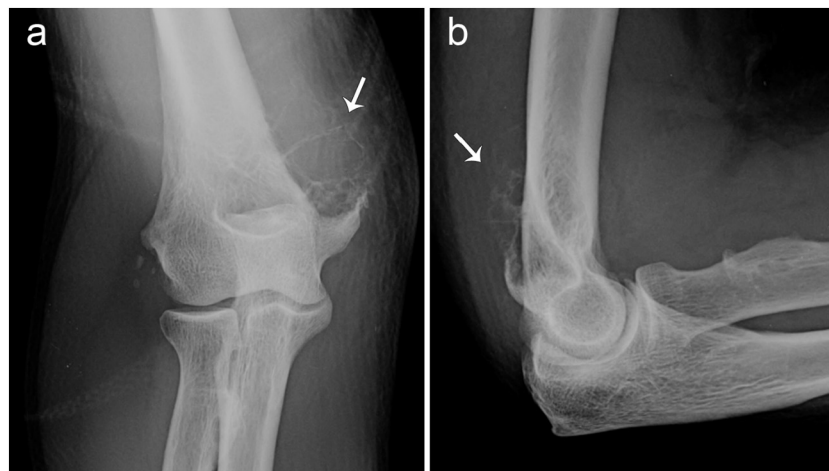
Anteroposterior (a) and lateral (b) radiographs of the right elbow demonstrate an eccentric expansile lytic lesion (arrows) of the medial aspect of the distal humeral metaphysis.
